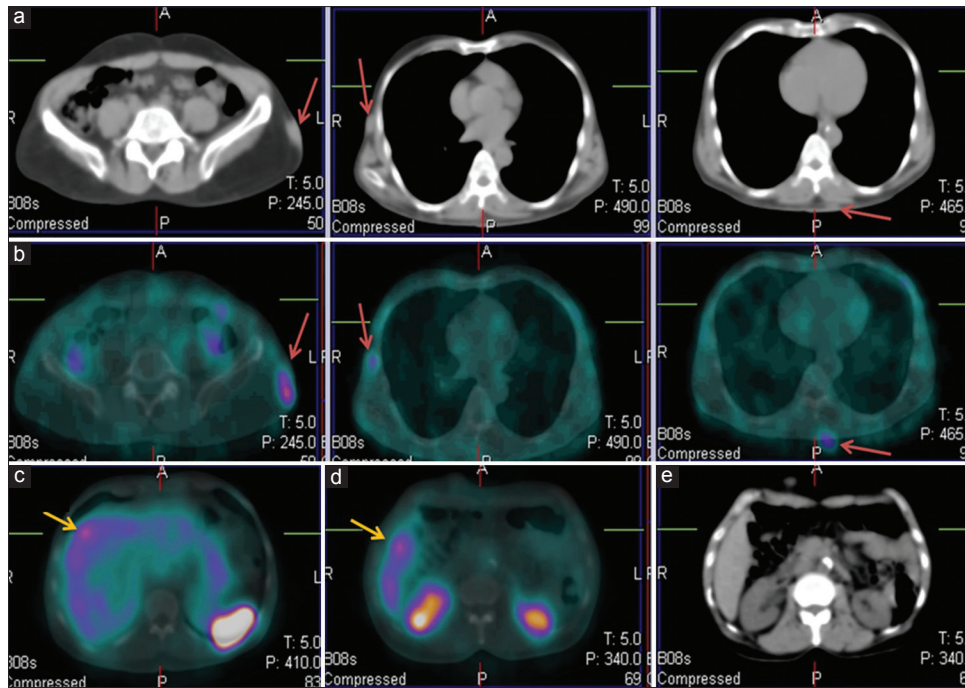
Tc-^{99m} labeled hydrazinonicotinyl-Tyr3-octreotide single-photon emission computed tomography images. (a) Row shows transaxial computed tomography images and (b) row shows the corresponding fused single-photon emission computed tomography images which reveal multiple soft-tissue density cutaneous and subcutaneous lesions at the left iliac region, right lateral aspect of the thorax, and in the posterior thoracic region which shows ^{99m}Tc labeled hydrazinonicotinyl-Tyr3-octreotide uptake (red arrows). Two focal increased uptakes are seen in the right lobe of the liver with no specific changes noted in the corresponding computed tomography images (orange arrows, c-e)
